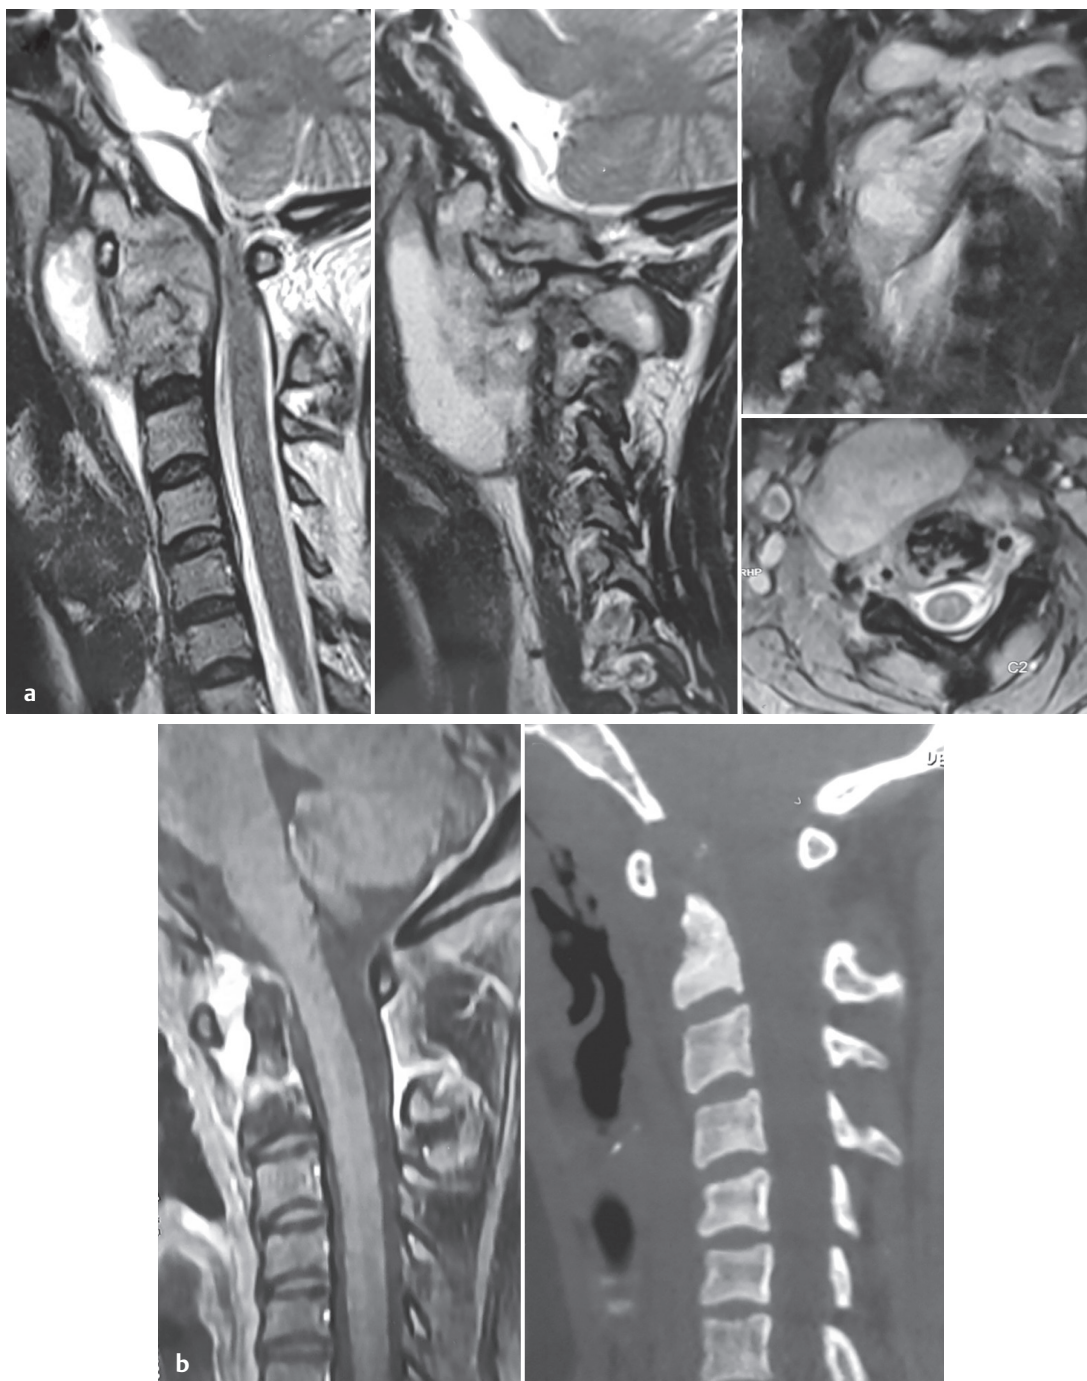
(a) Patient 1: T2-weighted MR images: showing a large anterolateral tuberculous abscess, granulation tissue involving odontoid and atlantoaxial dislocation (AAD). As the patient had minimal deficits, a percutaneous drainage of the abscess under cover of antitubercular therapy (ATT) along with the application of an external orthosis was adopted. (b) T1-weighted sagittal contrast MR image after 1.5 years of ATT, showing significant resolution of the granulation tissue and abscess as well as soft tissue edema. A small amount of enhancing granulation tissue is still seen anterior to the odontoid; the sagittal CT reconstructed CT image, however, shows AAD with canal compromise.
